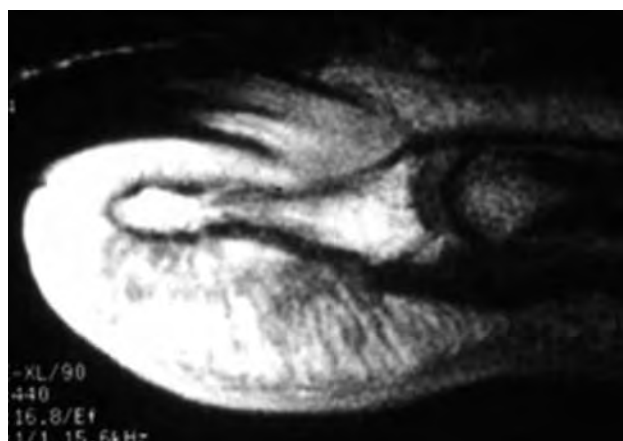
MRI showing a filamentous tufted tumor. © B. Richert
